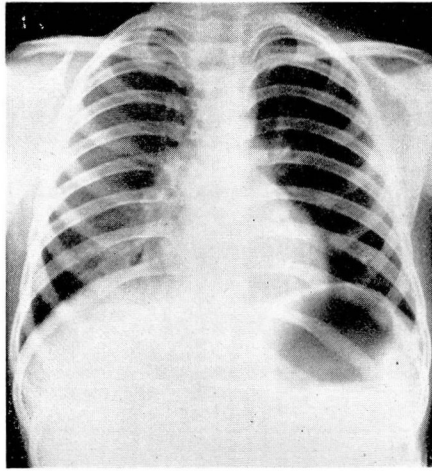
Case 2. Roentgenogram of chest.
